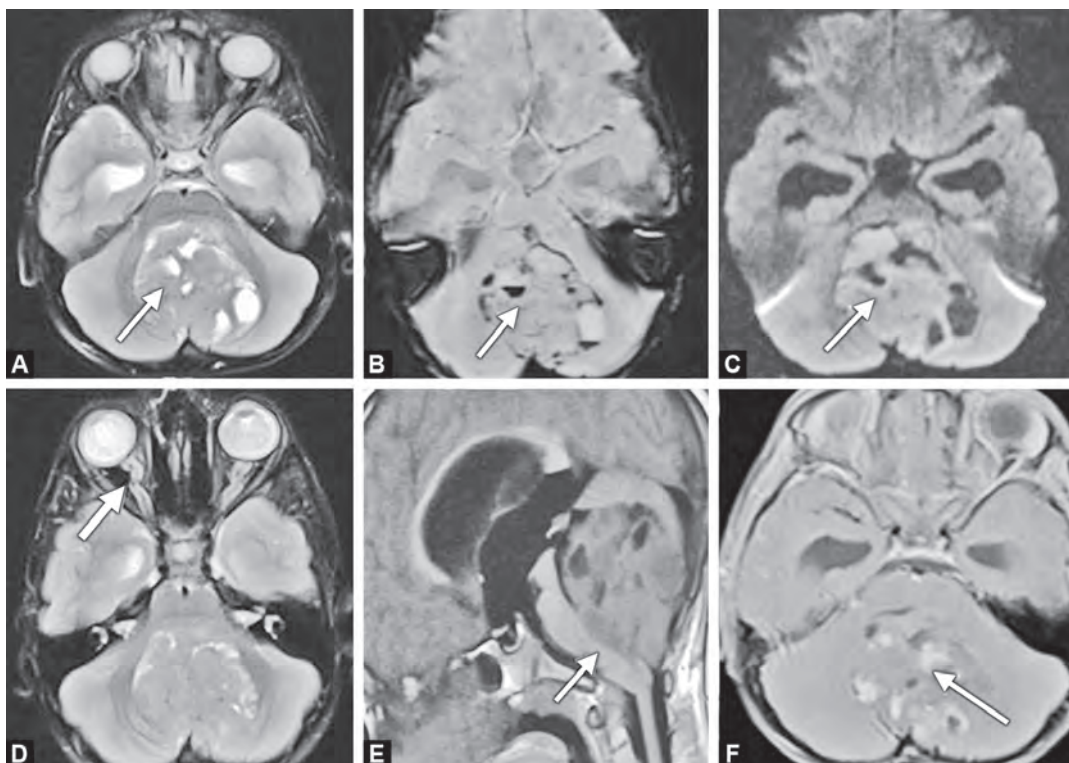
(A) Axial T2W image shows a solid-cystic mass centered within the fourth ventricle, causing a mass effect on the brainstem and cerebellum (arrow) with associated hydrocephalus in the visualized temporal horns. (B) Axial SWI image shows the cystic areas with multifocal blooming and blood levels (arrow). (C) Axial DWI shows restricted diffusion in the solid components of the mass (arrow). (D) In addition, axial T2W shows kinking and tortuosity of both optic nerves (arrow). (E) The sagittal T1W image shows intraventricular predominantly isointense mass causing compression and displacement of the brainstem (arrow) and marked supratentorial hydrocephalus. (F) Axial T1 post-contrast imaging reveals patchy enhancement within the mass (arrow)
